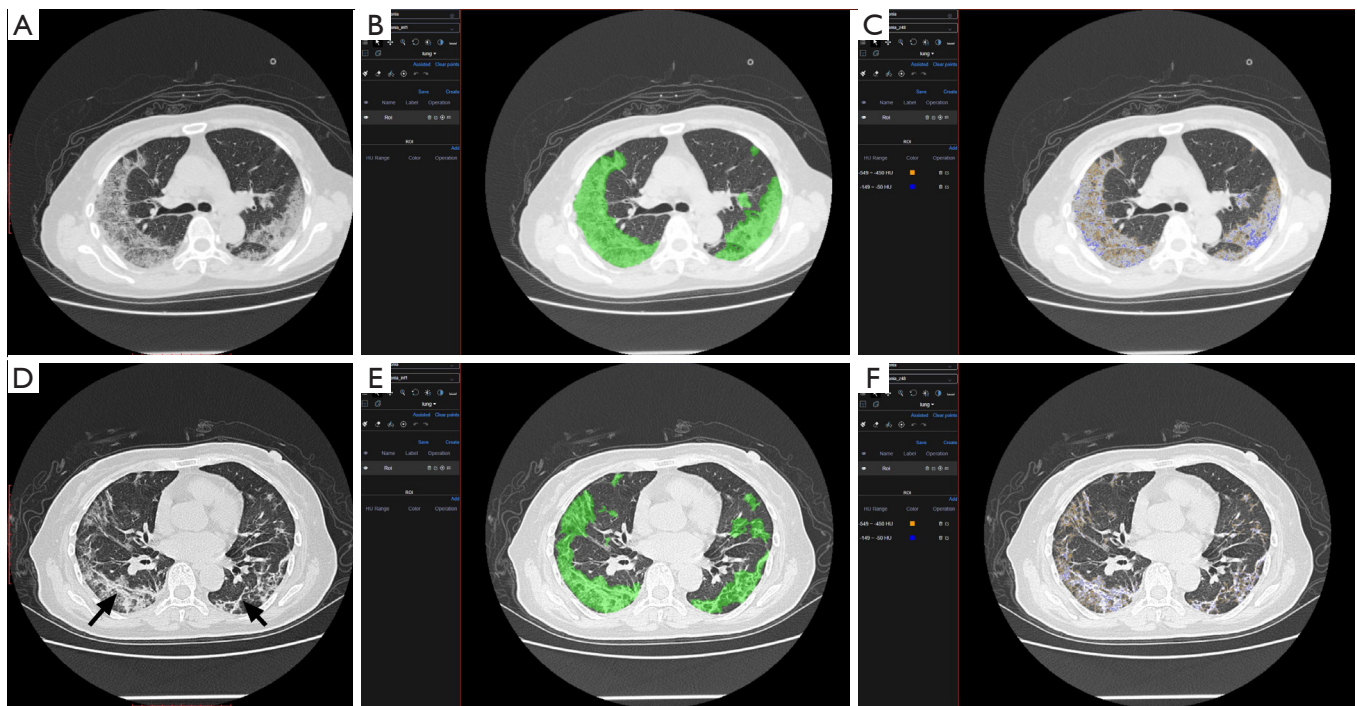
A 79-year-old female was diagnosed with severe COVID-19. After seven days treatment, her symptoms relieved. (A,B,C) However, the chest CT showed that the area of infection increased rapidly. The quantitative analysis result showed several zone 4 area interval density in her infectious area. Her symptoms deteriorated the next day, and the gas arterial blood gas analysis showed ARDS. (D,E,F) After 12 days' treatment, another Quantitative CT analysis result showed the area of Zone4 decrease while the area of zone 8 increase (the zone 8 density mainly distributed in fibrous tissue area, black arrow in D), which could indicate the disease was on the mend. COVID-19, coronavirus disease 2019; CT, computed tomography.
